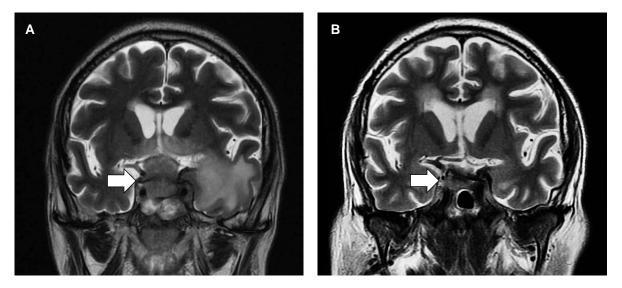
Coronal T2, contrast-enhanced sequence of the magnetic resonance imaging of case 3, showing tumor volume before (left, white arrow) and after (right, white arrow) chemotherapy.
